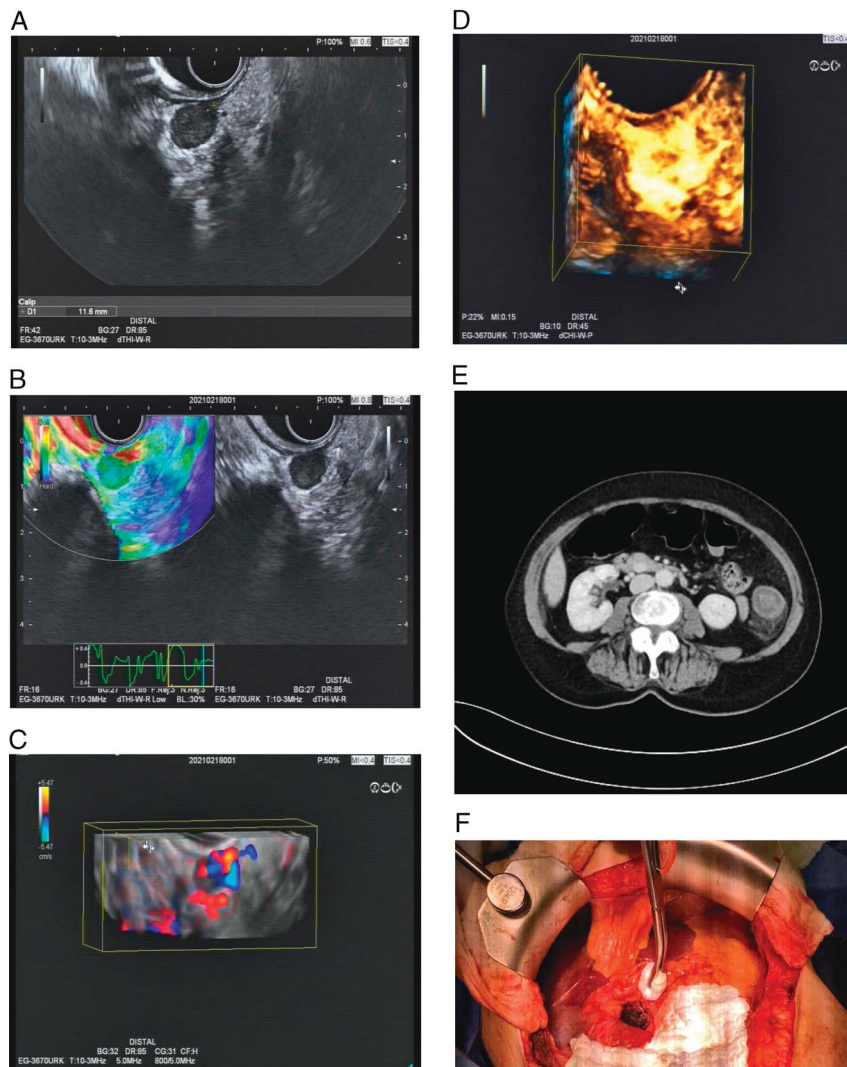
A 79-year-old woman with a suspected neuroendocrine tumor of the pancreatic head. The tumor could be enucleated during surgery and turned out to be a benign angiomyolipoma of the pancreatic head. EUS shows a hypoechoic tumor in the uncinate region of the pancreas with a very good delineation (A). The tumor appears green, indicating soft tissue in elastography (B). In 3-dimensional EUS with color Doppler imaging, the tumor shows lots of vessels in keeping with a neuroendocrine lesion of the pancreas (C). After administration of 4.8 mL SonoVue in contrast mode, the tumor clearly shows high vascularization in this 3-dimensional imaging (D). The tumor can be reproduced on top of the vena cava in the uncinate region of the pancreas; no metastasis are detected in a full body scan (E). The tumor appears highly vascularized during surgery but could be successfully enucleated from the pancreas (F). Image source of CT: Dr H.-J. Hald, Helios Hospital Meiningen, Radiology.
